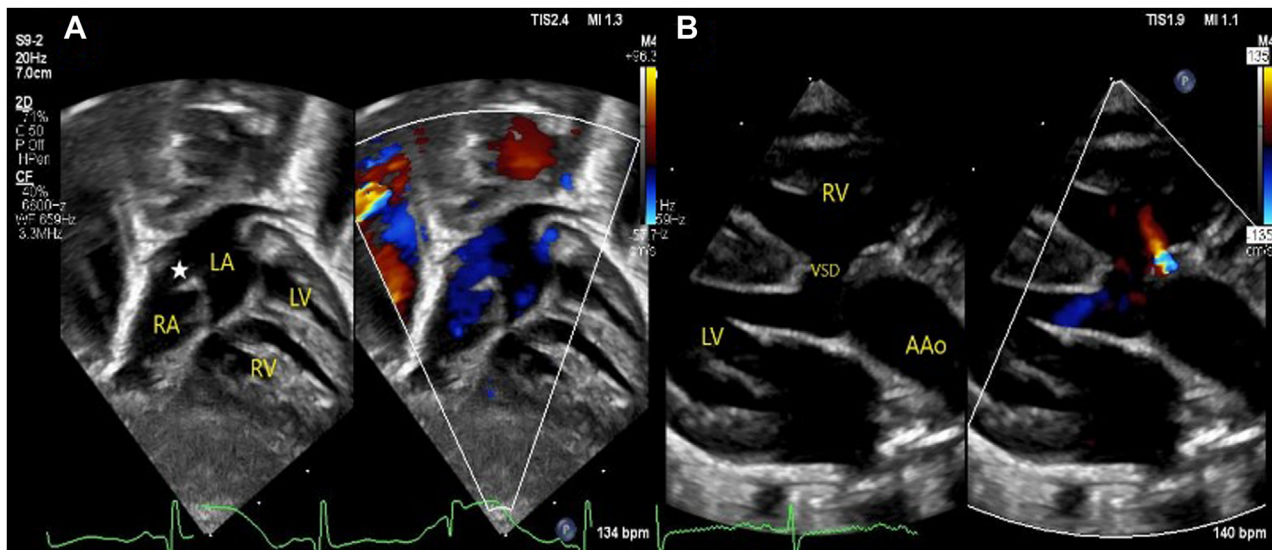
Atrial septal defect and AR after fall in PVR. (A) Two-dimensional TTE, subcostal long-axis view of the small ASD (white star) without (left) and with (right) color-flow Doppler, demonstrates a right-to-left shunt in the setting of normal pulmonary venous return related to the ongoing discrepancy between right and left atrial compliance from decreased pulmonary venous return. (B) Two-dimensional TTE, parasternal long-axis view of the aortic valve without (left) and with (right) color-flow Doppler, demonstrates mild AR in the setting of lower PVR. AAo, Ascending aorta; LA, left atrium; RA, right atrium; RV, right ventricle.
